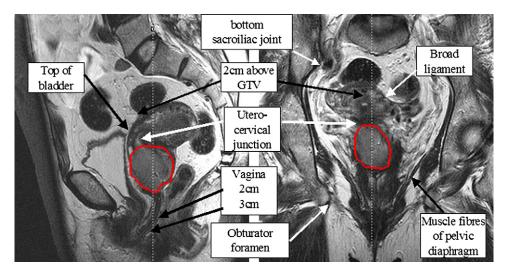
Sagittal and coronal T_2 -weighted MR images of a patient showing the different definitions of superior and inferior parametrial boundaries from survey respondents. Red contour = GTV.
